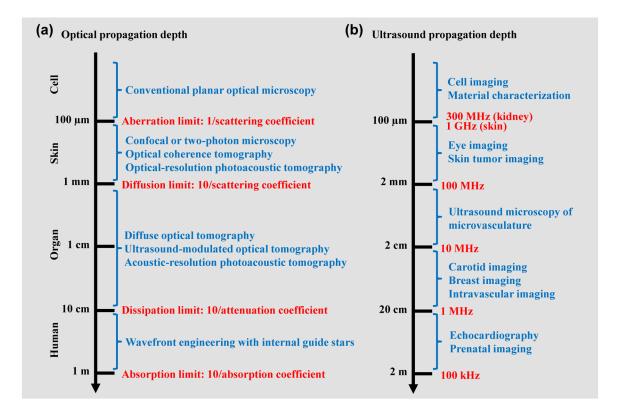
Photon and ultrasound propagation regimes in soft tissue
